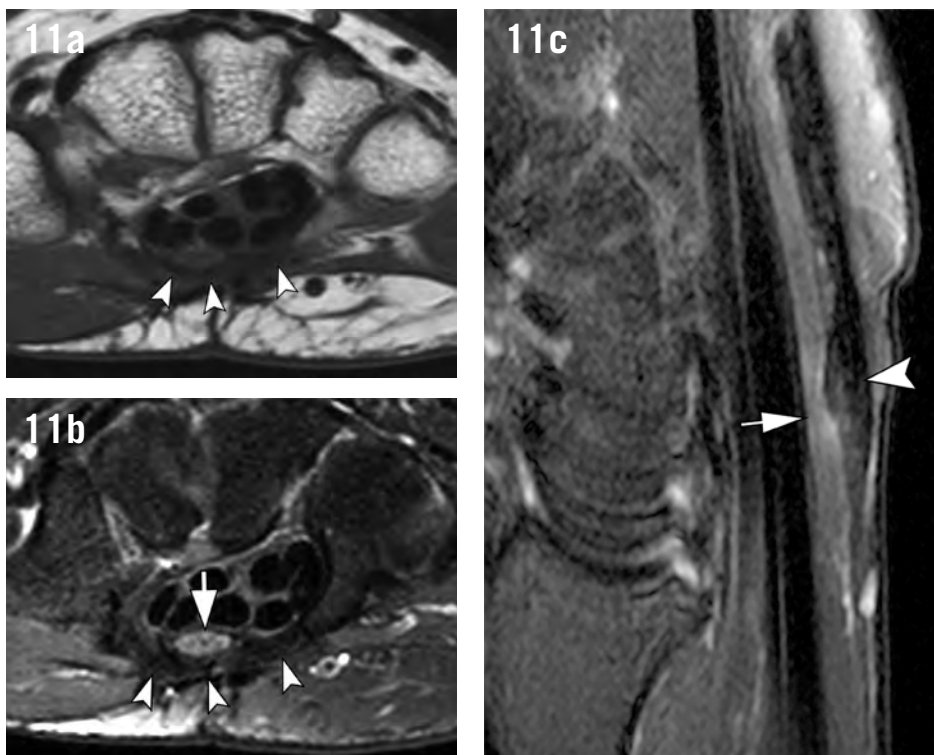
Post-operative carpal tunnel syndrome. Axial (a) T1-weighted and (b) T2-weighted fat-suppressed images of the wrist at the level of the distal carpal tunnel. Sagittal T2-weighted fat-suppressed image of the wrist shows the longitudinal axis of the median nerve (c). There is an incomplete flexor retinaculum release with fibrous tissue and thickening (arrowheads). The median nerve is flattened with increased signal (arrows).
